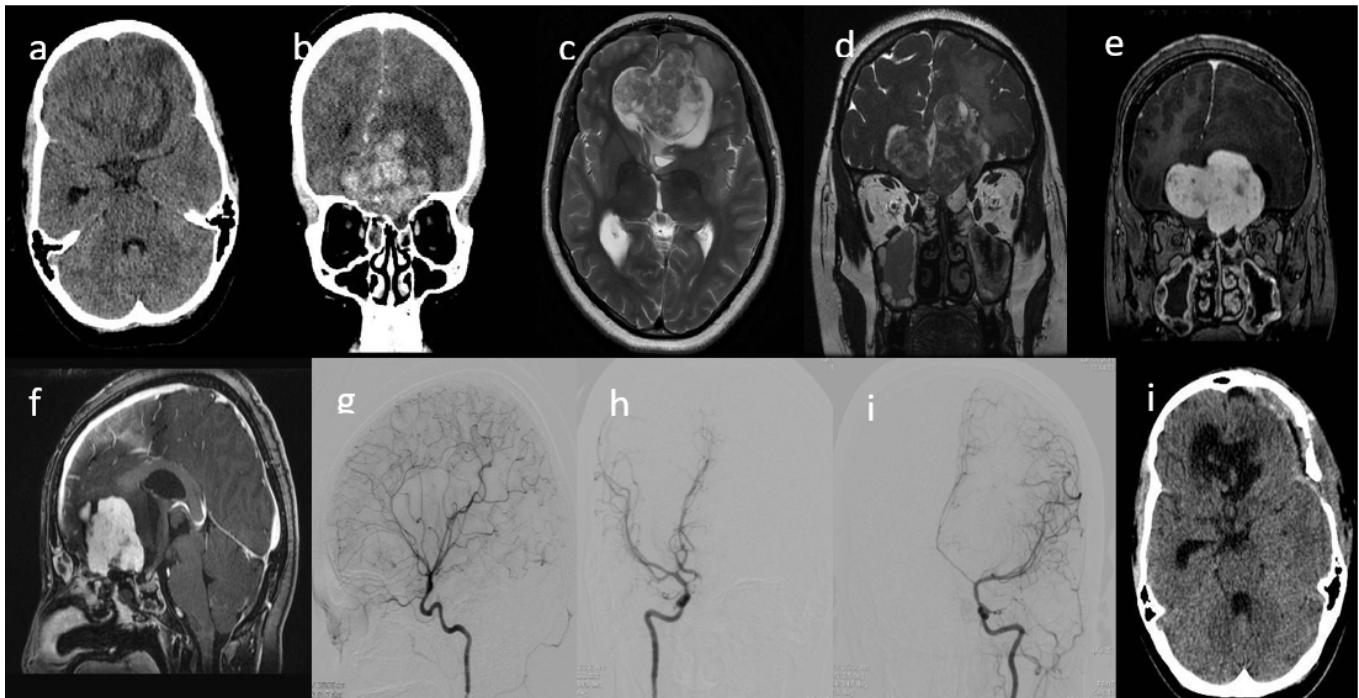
Axial plain (a) and coronal contrast (b) CT cuts show iso to hypodense extraaxial lesion arising from anterior cranial fossa with heterogeneous contrast enhancement and mass effect and edema in adjacent parenchyma. T2WI axial (c) and coronal (d) cuts show predominantly solid, iso to hyperintense lesion with interspersed cystic areas and foci of micro-hemorrhages. On coronal (e) and sagittal (f) contrast images, a well-defined lobulated heterogeneous intensely enhancing mass in anterior cranial fossa with no dural tail is seen. The lesion appears to arise from left cribriform plate. Angiograms (g, h and i) show mild tumor blush in anterior cranial fossa with arterial feeders from ACA along with superior displacement of orbitofrontal branch of right ACA and postero-superior displacement of the right A2 ACA. Left A1 ACA is stretched and displaced superiorly and laterally while left A2 ACA is displaced to right side. Axial CT (j) shows postop changes with complete resection of the tumor.
